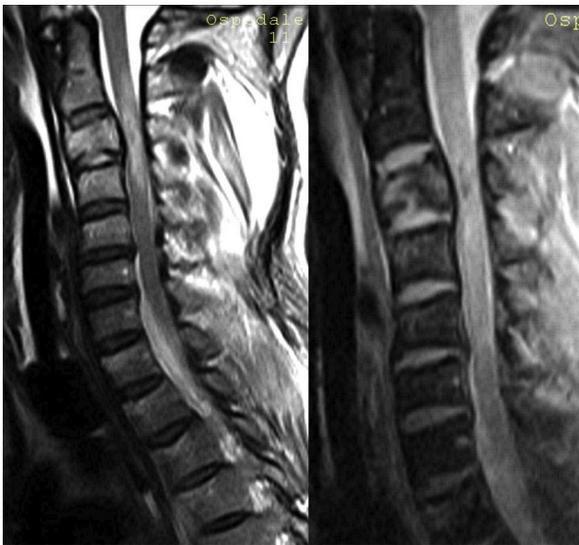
(a and b) A 39-year-old-man victim of diving trauma. Sagittal midline FSE T2-weighted (a) and GRE T2*-weighted (b) MR images. Typical pure compressive trauma to head vertex causing burst fracture of C3 vertebral body and compression fractures of superior endplates of C7 to D2 vertebral bodies. Spinal cord edema with spindle-shaped enlargement spanning from C2 to C4 containing central hypointense spots of hemorrhage at epicenter of trauma visible only with the more sensitive GRE sequence.
